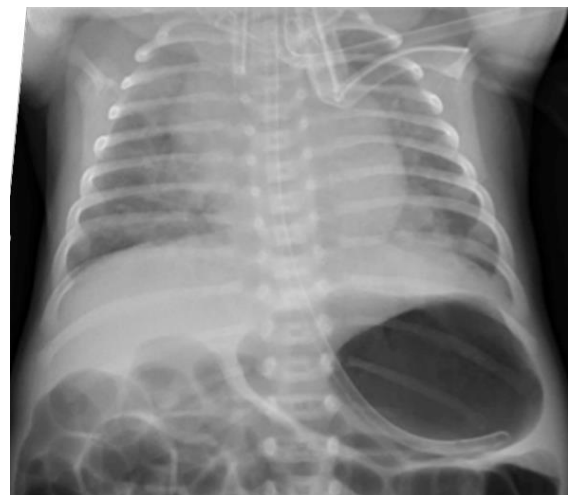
Chest X-ray showing the NGT in the stomach with significant gastric inflation from a suspected TOF
